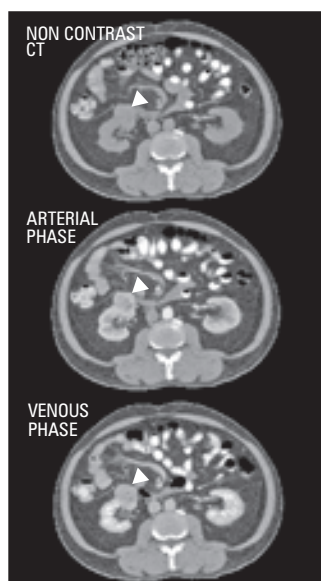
Triphasic CT of a Renal Cell Carcinoma – showing arterial enhancement and venous de-enhancement
